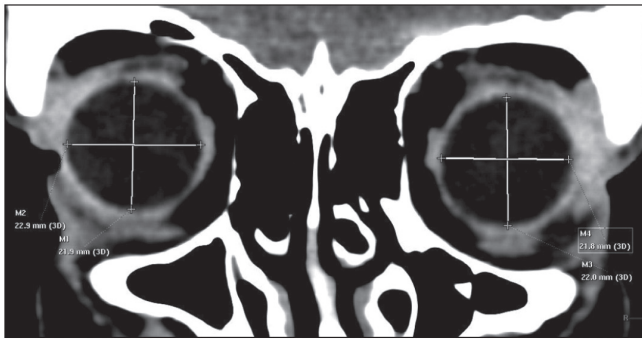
Coronal CT reformat of the eyeballs/globes showing the craniocaudal diameters (lines M1 and M3) and coronal plane transverse diameters (lines M2 and M4) of the eyeballs
